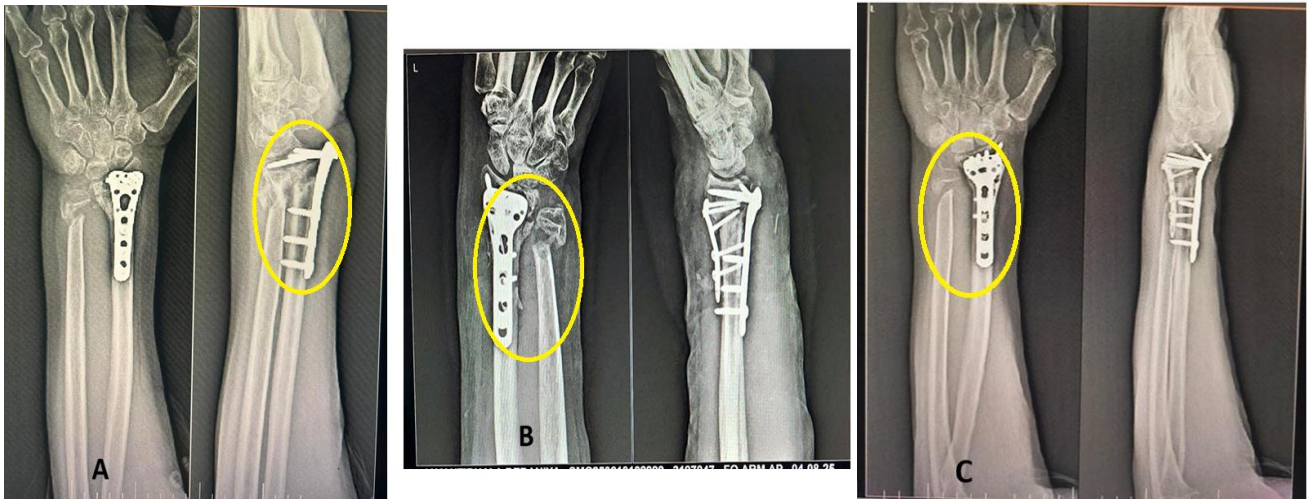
(A) Preoperative anteroposterior and lateral radiograph of a 65-year-old male demonstrating atrophic non-union and plate failure of the distal radius; (B): Immediate postoperative radiographs after implant removal, revision plating, and autologous bone grafting (ulna left side without DNVD after 7 months of index surgery); (C): Anteroposterior and lateral X-ray of forearm with wrist at 2 months demonstrating restoration of wrist alignment.
